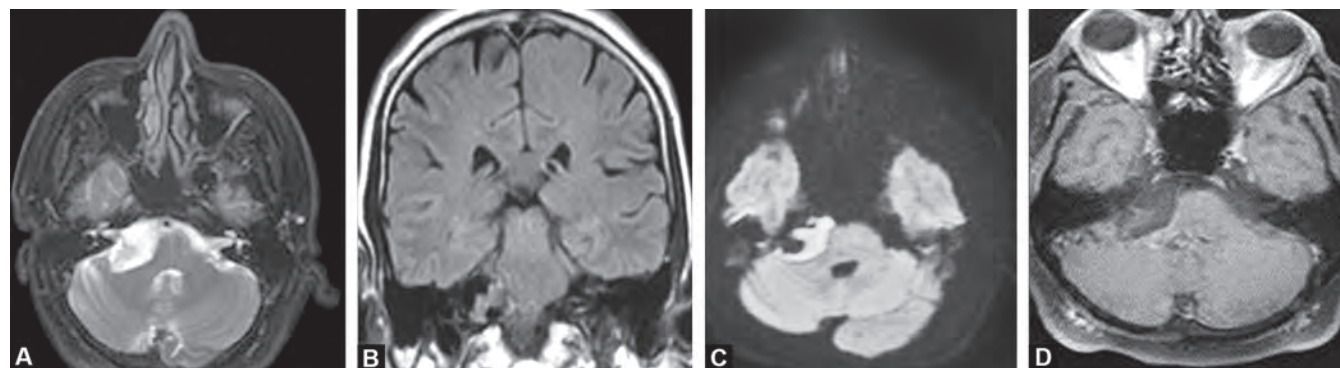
(A) Axial T2WI image shows a lobulated hyperintense extra-axial lesion in the right cerebellopontine angle with incomplete suppression on FLAIR (B), with restricted diffusion on DWI (C). The lesion demonstrates no enhancement on post-contrast T1-weighted imaging (D)
